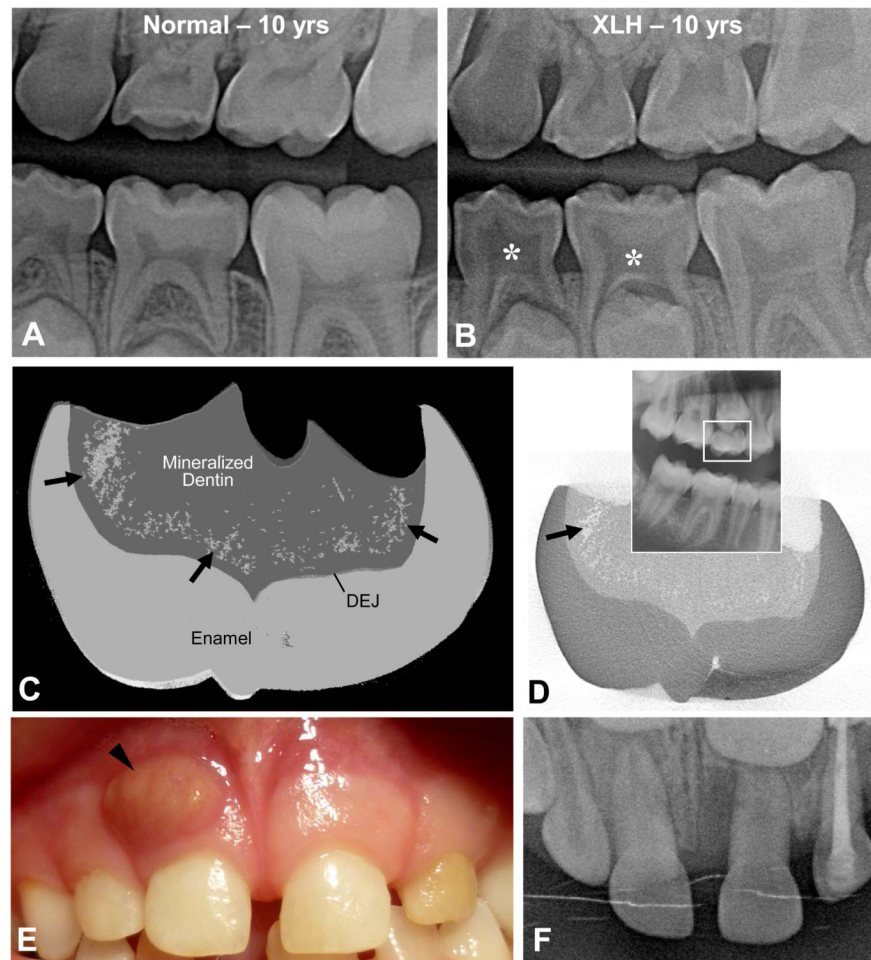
(A,B) Tooth radiographs from a normal, 10-year-old male, and from a 10-year-old male patient with X-linked hypophosphatemia (XLH) caused by an inactivating mutation in the *PHEX* gene. In deciduous molars, note the enlarged pulp chambers (asterisks), the prominent pulp horns, and the radiolucency of the hypomineralized dentin that mineralized prior to the onset of systemic treatment. (C,D) Micro-computed tomography of a crown from the upper-right, second deciduous molar (seen on the panoramic X-ray inset) of a 13-year-old female X-linked hypophosphatemia female patient with a mutation in the *PHEX* gene. Mineralization voids (the spotty areas indicated by the arrows in panel C accumulating in the dentin near the dentino-enamel junction (DEJ) were rendered in grey using 3D reconstruction software to compile volumetric data from the 2D X-ray “slices,” one of which is depicted in panel D where the mineralization voids appear white. (E,F) Photograph and occlusal X-ray of the upper central right deciduous incisor from a 6-year-old X-linked hypophosphatemia male patient with a mutation of the *PHEX* gene. A large abscess (arrowhead) is observed related to the incisor root; the tooth was extracted after systemic treatment with antibiotics.
